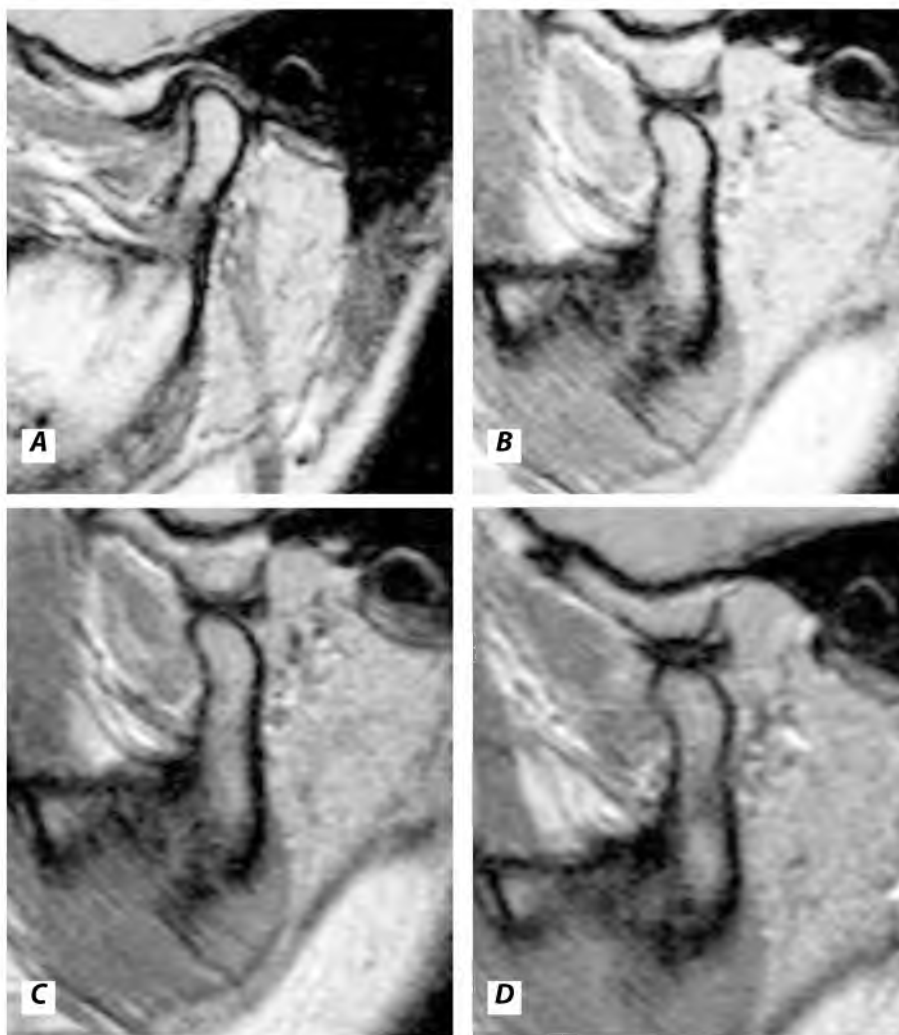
MR Imaging of the TMJ after treatment: (A, B) A closed-mouth sagittal T1-weighted images shows a normal relationship of the mandibular condyle, the disk at the 11 o'clock position, the temporal fossa and the articular eminence; (C, D) Open-mouth sagittal T1-weighted images shows the normal position of the disk between the mandibular condyle and articular eminence
